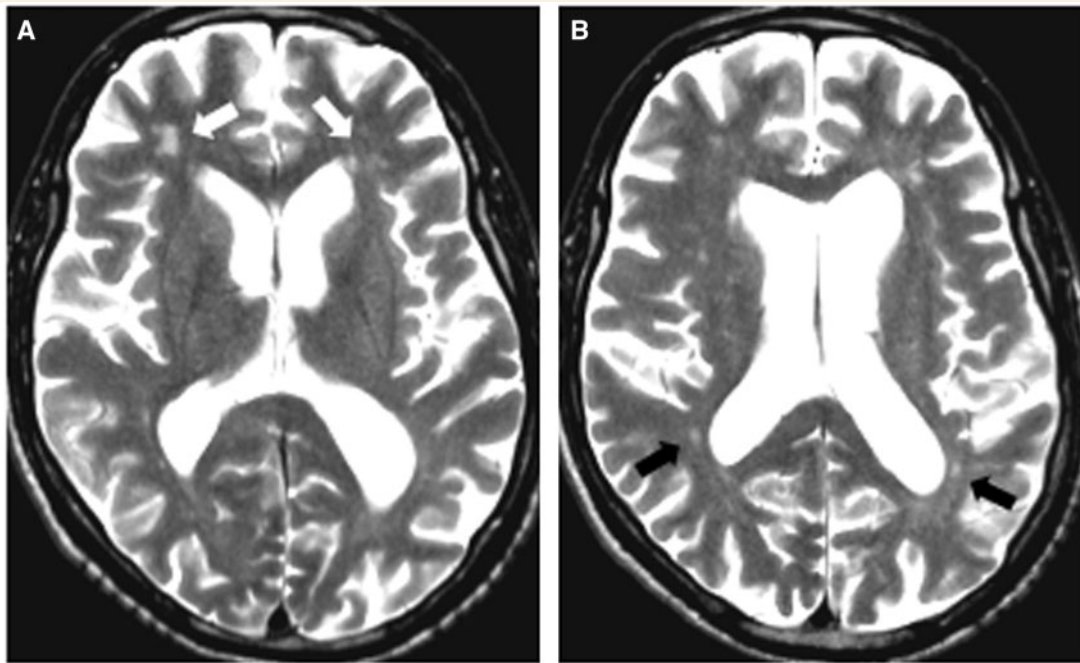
MRI findings in HDLS. Affected sibling Patient II-2: 60-year-old male with progressive cognitive deterioration and motor problems. His MRI shows enlarged ventricles with diffuse patchy white matter lesions more prominent in the frontal (A, white arrows) than in the posterior regions (B, black arrows). There is no contrast enhancement present.
